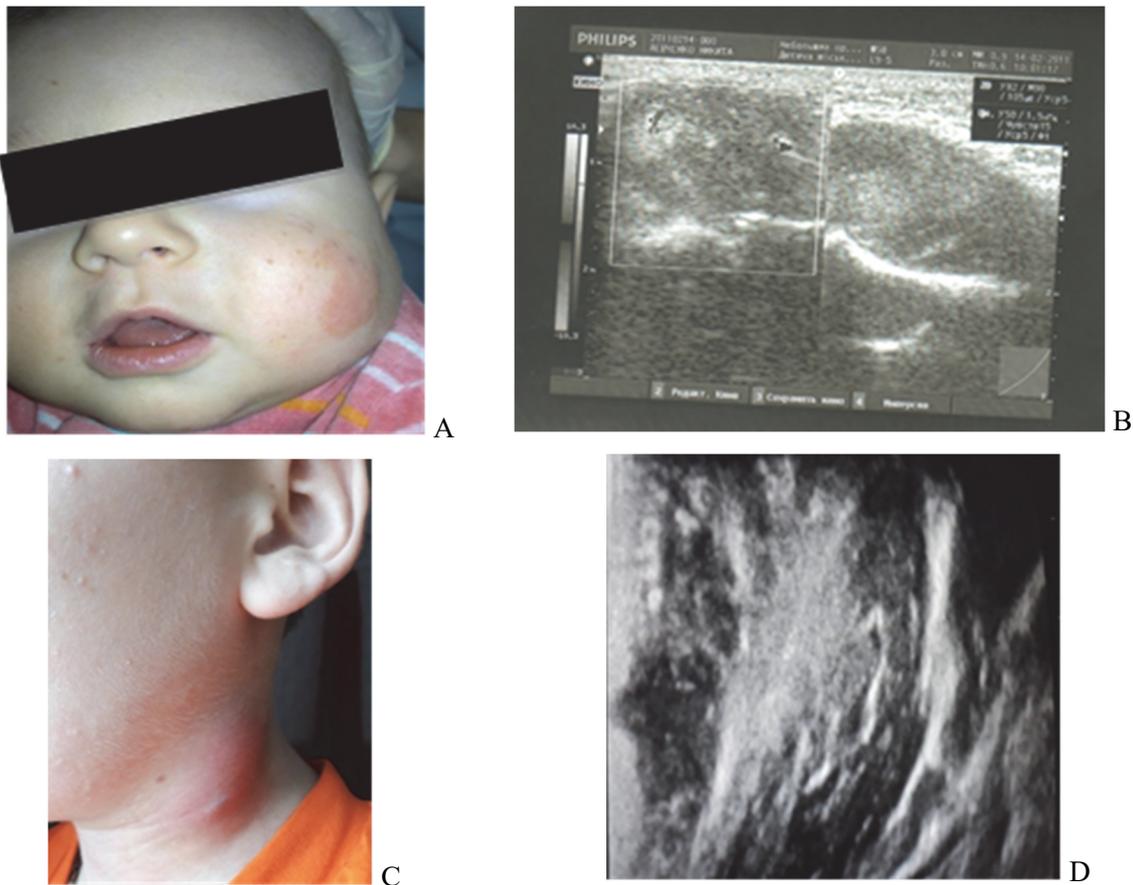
Appearance of children with lymphangioma of the left cheek (A) and suppurating lymphangioma of the left neck (C) and their ultrasound images, respectively. B – oval hypo- and hyperechoic areas with clear boundaries and smooth contours, D – non-contoured purulent focus with no clear structure.
